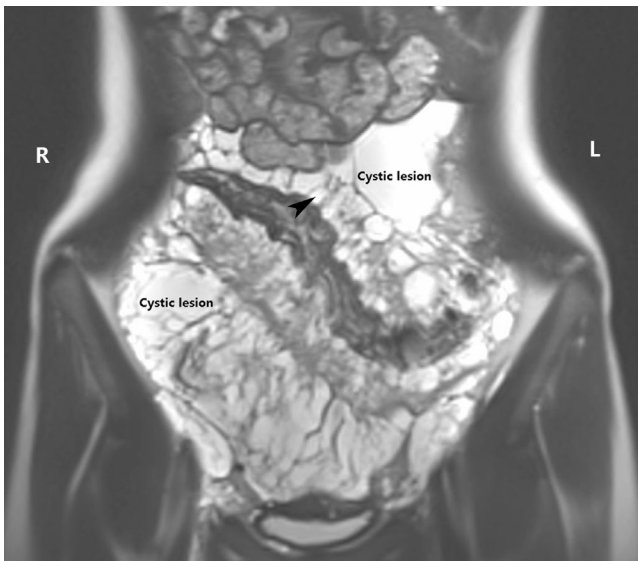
Coronal pelvic T2-weighted magnetic resonance image showing multiple mesenteric microcysts (*arrow-head*) and mesenteric macrocyst. These findings implied intestinal lymphangiectasia.
